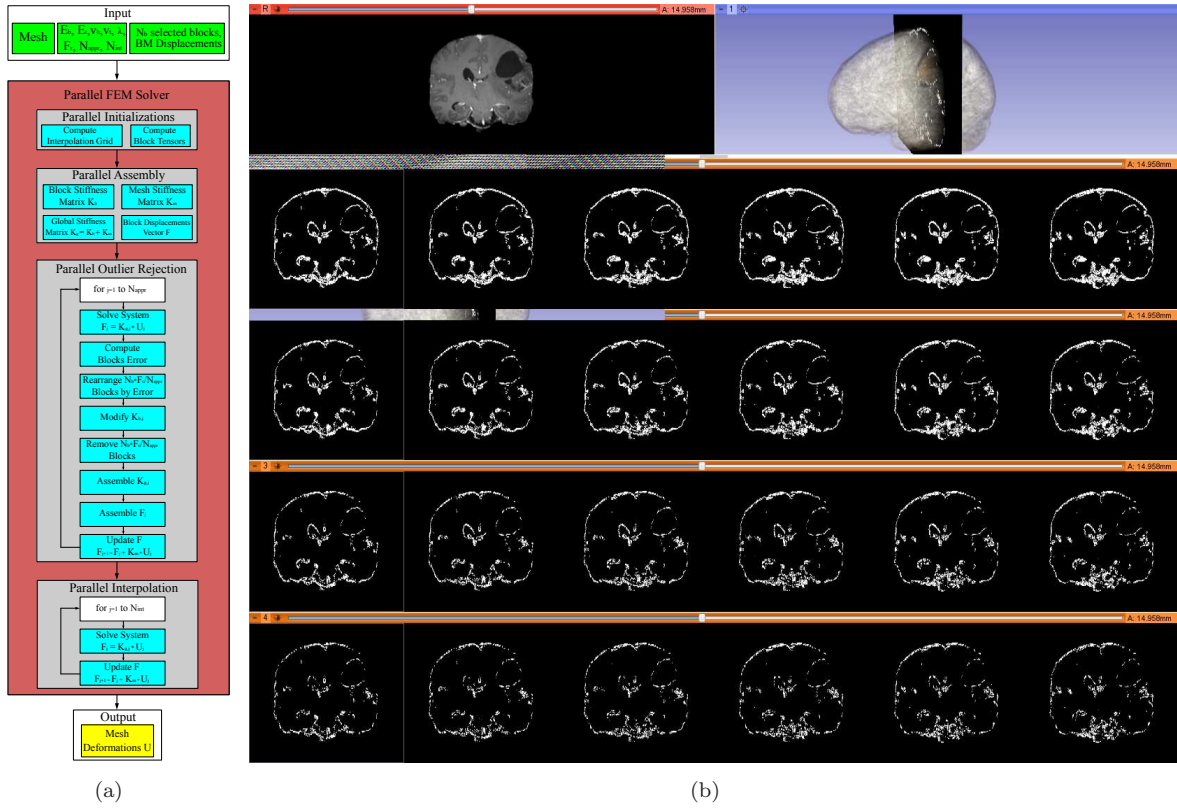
(a): The Parallel FEM Solver (PFEMS). Green represents the input, gray the PFEMS steps, cyan the components of each step, and yellow the output. (b): The selected blocks before and after the Parallel Outlier Rejection step. The image blocks are depicted on six consecutive coronal MRI slices. From top to bottom row: coronal pre-op MRI slice (left) and its position in the volume MRI (right); blocks before rejection ($N_b = 318026$); blocks after rejection with $F_r = 10\%$ (286226); blocks after rejection with $F_r = 25\%$ (238521); blocks after rejection with $F_r = 40\%$ (190816).
